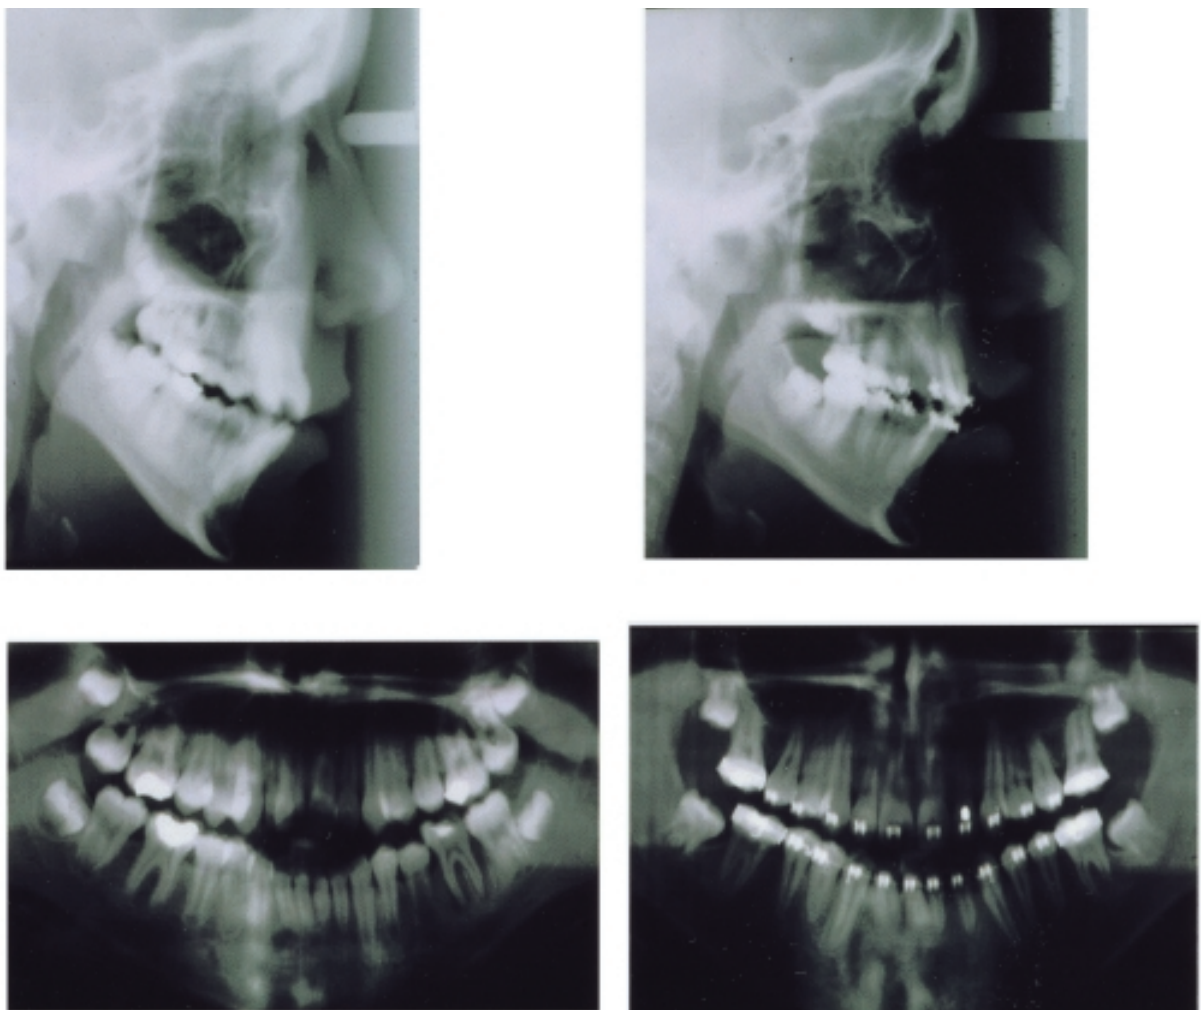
Radiographs pre-treatment and near the end of treatment.
